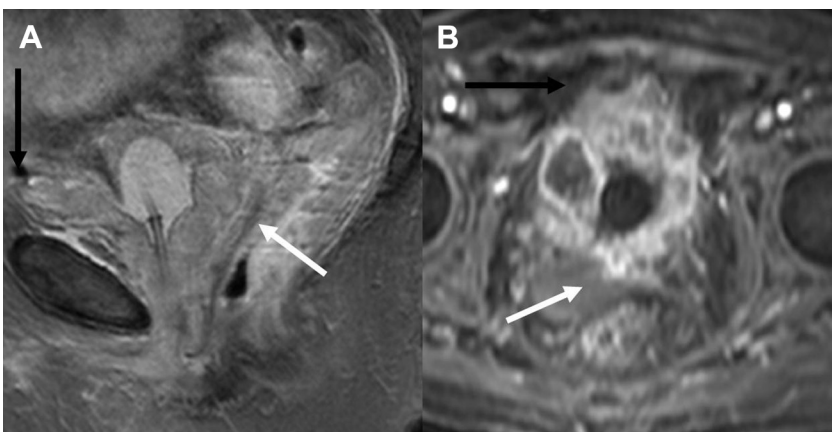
T2-weighted (A) sagittal and T1 FS postcontrast (B) axial images. *White arrow* indicates rectal invasion, *black arrow* indicates abdominal wall invasion, both in keeping with stage T4b.
